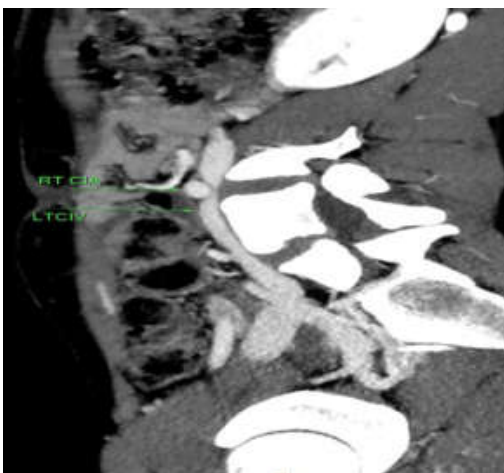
CT Peripheral Angiogram.
